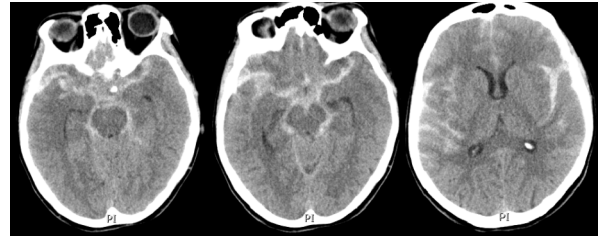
a,b,c Axial noncontrast-enhanced computed tomography (CT) indicates a suspicious right MCA aneurysmatic rupture (Department of Radiology, Cantonal Hospital Zenica, 2016)
